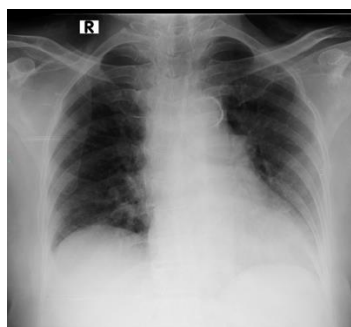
Chest X-ray Examination
